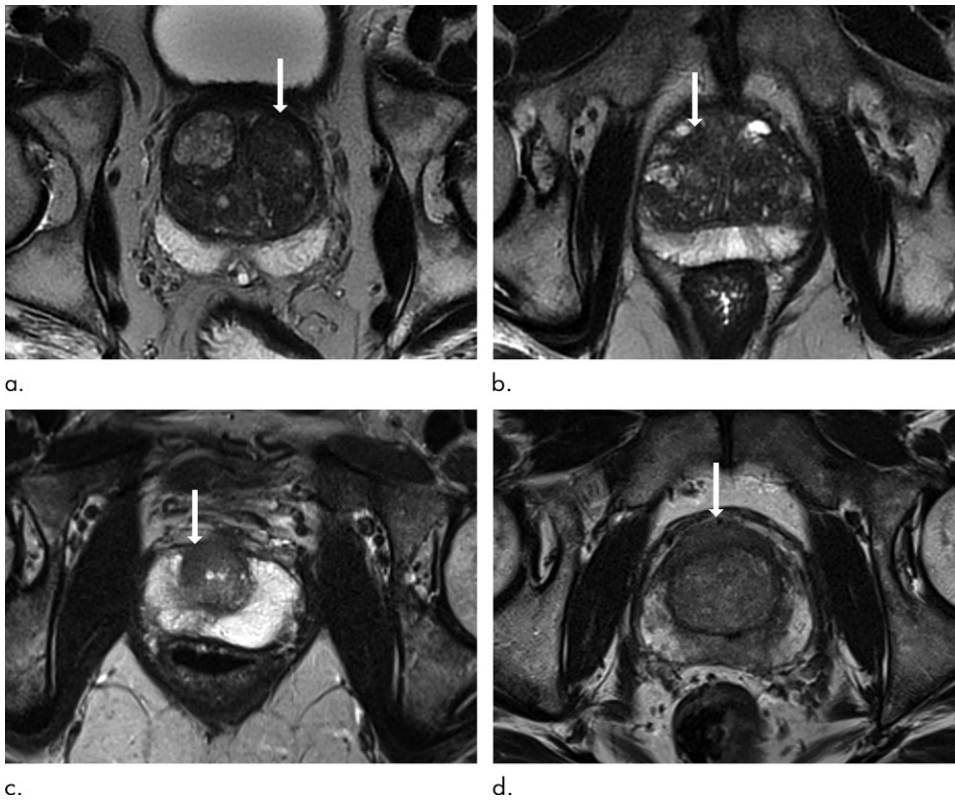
T2-weighted MRI scans show representative transition zone lesions (arrow). (a) Prostate Imaging Reporting and Data System (PI-RADS) score 2. Image shows encapsulated, mildly heterogeneous nodule in left midgland to base with predominantly low signal intensity. (b) PI-RADS score 3. Image shows heterogeneous signal intensity with ill-defined margins in right midgland. (c) PI-RADS score 4. Image shows small, noncircumscribed lesion with homogeneous and moderately low signal intensity at right apex to midgland level. (d) PI-RADS score 5. Image shows bilateral midgland, large lenticular lesion in midgland with homogeneous and moderately low signal intensity that extends into the anterior fibromuscular stroma.
